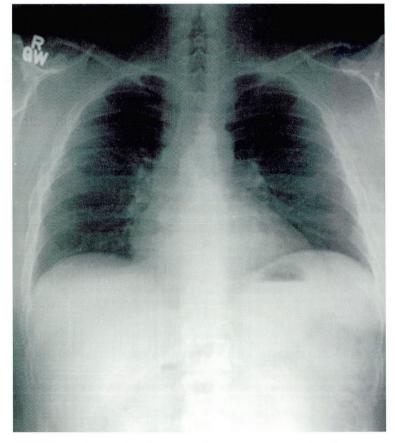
The patient's presenting posteroanterior chest radiograph, which is normal.
